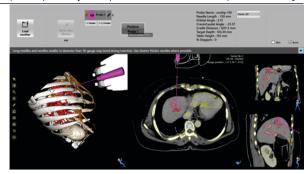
Robot-assisted Navigation system for CT-guided percutaneous lung procedures. Planning the procedure in the provided software.
